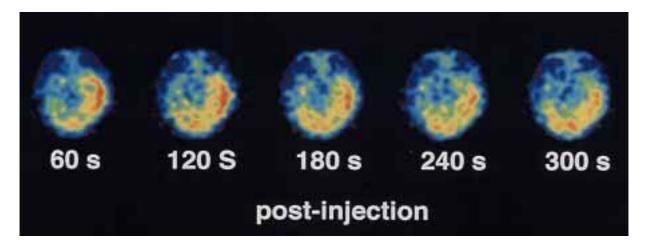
Dynamic Tc-99m ECD SPECT images obtained 3 days after the onset of the symptoms reveal marked hyperactivity in the left temporal lobe immediately after tracer injection, followed by a subsequent slight decrease in tracer activity.
